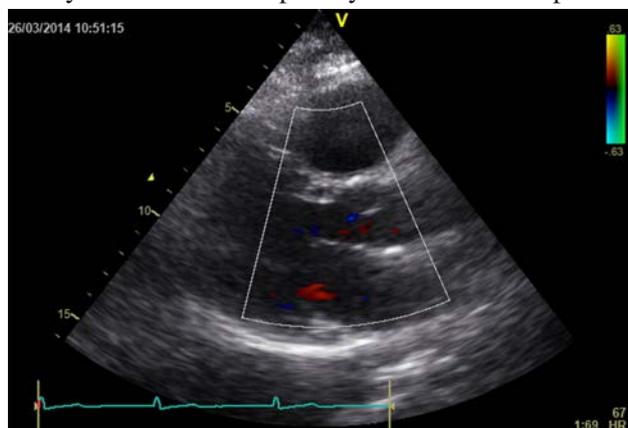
Transthoracic echocardiogram depicting the prosthesis of A. Ascendens.
